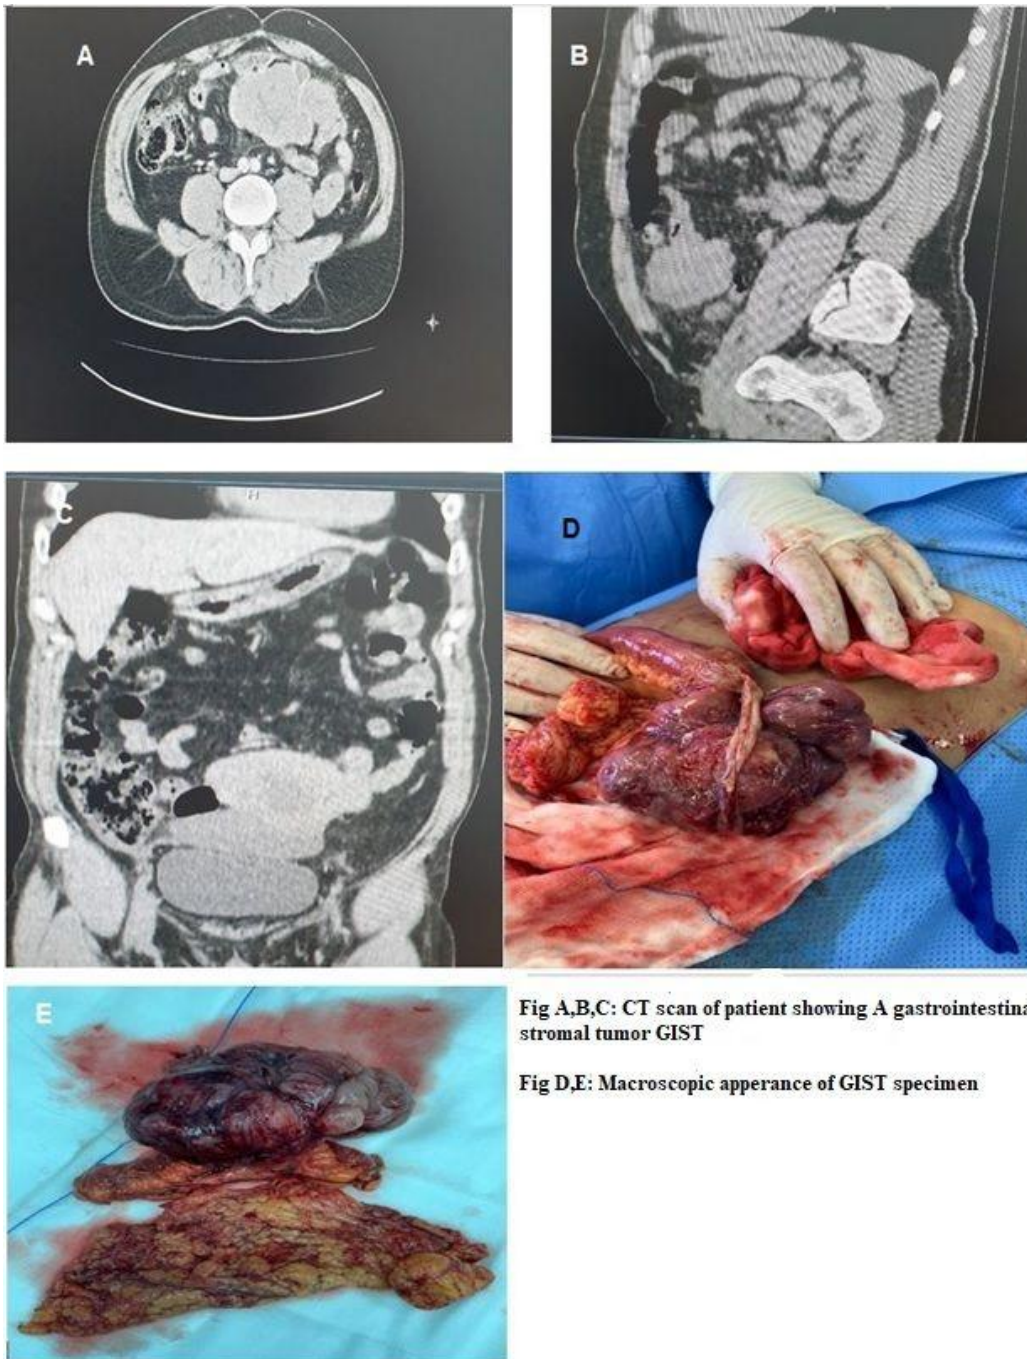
Fig A,B,C: CT scan of patient showing A gastrointestinal stromal tumor GIST
